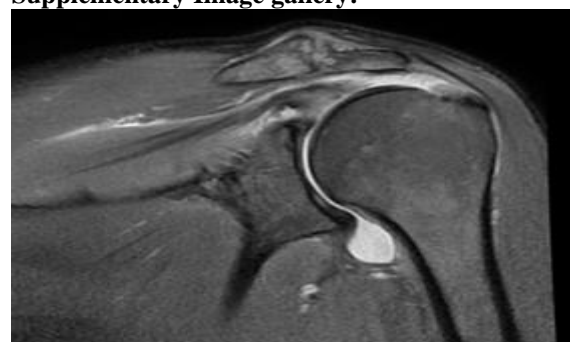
MRI Coronal PD FS sequence of left shoulder showing a complete tear of the supraspinatus tendon, with retracted fibres and significant fluid collection and joint effusion.
